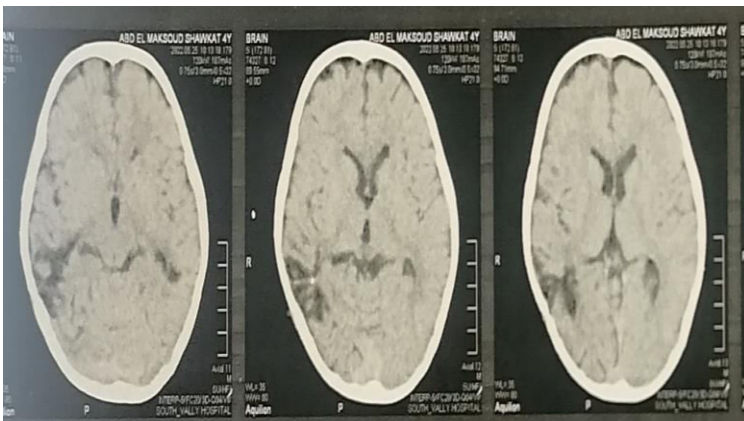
Postoperative CT scan images: Follow up CT brain after 3 months, showing encephalomalacia at site of hematoma.
